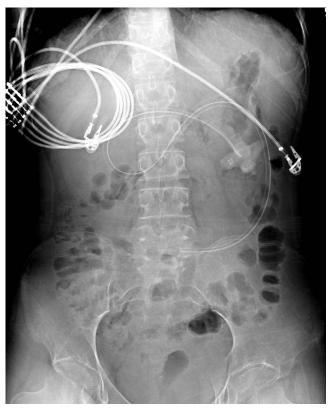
An abdominal radiograph confirms the proper placement of the GJ tube.
